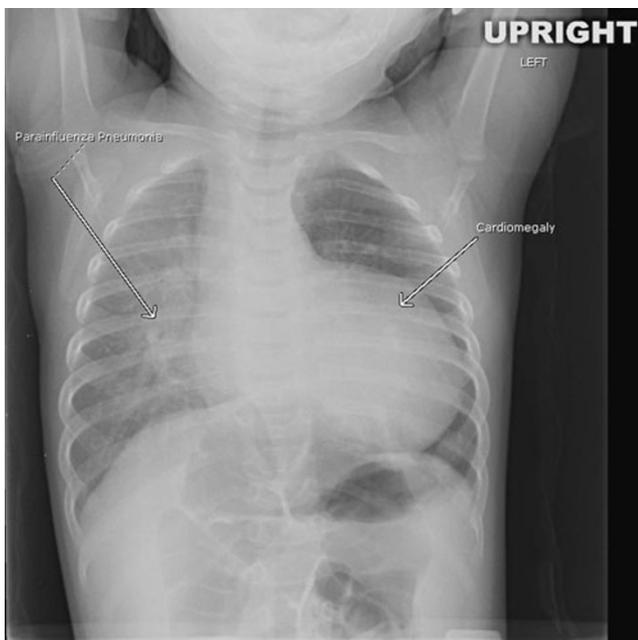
Anteroposterior chest X-ray showing cardiomegaly and parainfluenza pneumonia
